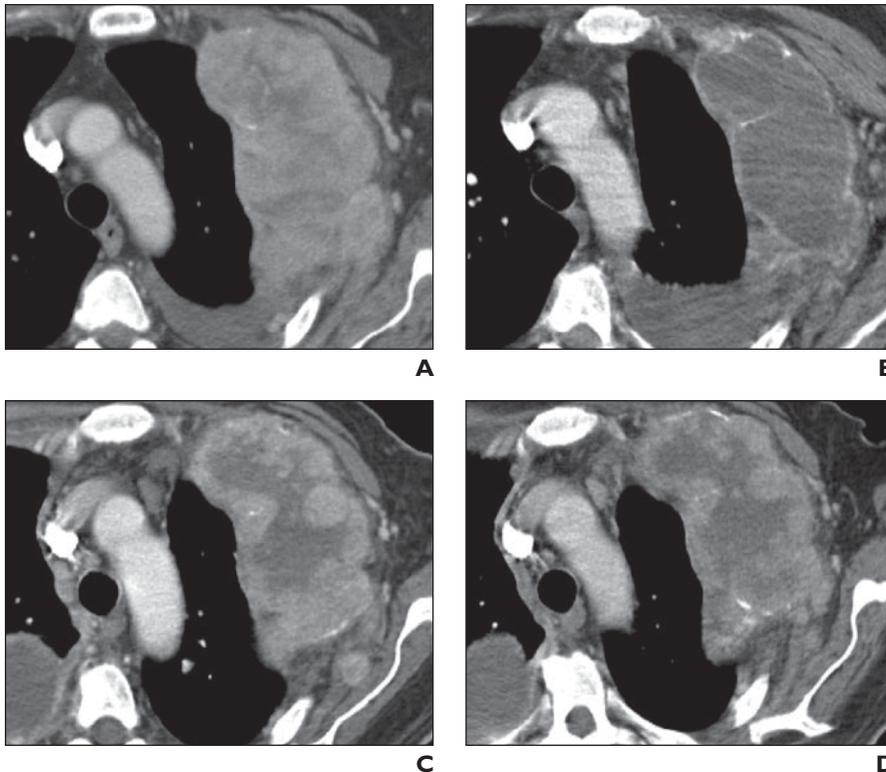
58-year-old man with metastatic renal cell carcinoma (RCC). Contrast-enhanced CT (CECT) depicts RCC metastasis in left chest wall at various stages of sorafenib therapy. A, CECT scan obtained 38 days before initiating therapy shows solid enhancing chest wall metastasis (mean attenuation, 72 HU). B, CECT scan obtained 59 days after initiating therapy shows markedly decreased enhancement and decreased attenuation (> 40 HU) of tumor, especially centrally. Mean attenuation of tumor is 28 HU. Note thin peripheral rim of enhancement, marked central necrosis, and minimal overall change in longest axial dimension size. C, CECT scan obtained 423 days after initiating therapy shows marked central fill-in of solid enhancing tumor with interval increase in size of mediastinal lymph nodes and development of loculated right pleural effusion, although tumor measurements do not yet meet size criterion for progressive disease according to Response Evaluation Criteria in Solid Tumors (RECIST). Mean attenuation of tumor is 55 HU. D, CECT scan obtained 483 days after initiating therapy shows marked central fill-in with overall RECIST progressive disease by size progression of mediastinal and pleural metastases (not shown). Mean attenuation of tumor is 64 HU.
